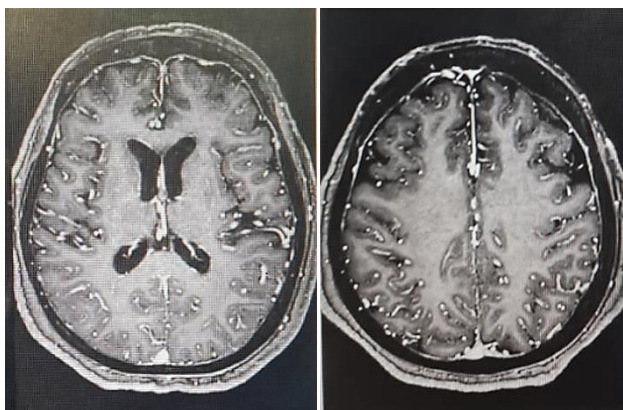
Brain MRI reveals diffuse dural thickening with abnormal leptomeningeal enhancement in both the left and right cerebral hemispheres.
